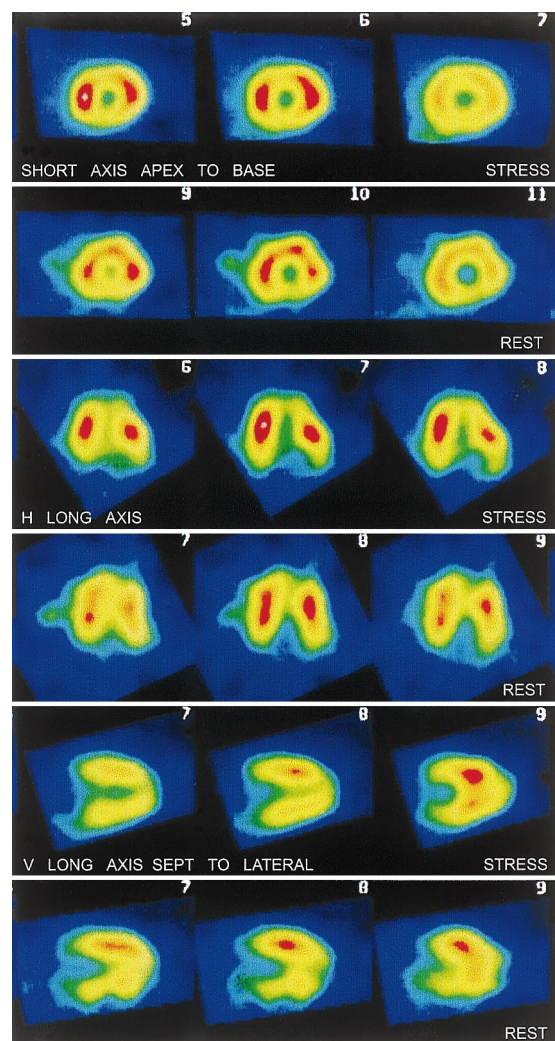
^{201}Tl SPECT at rest, and after dipyridamole stress test, in patient N66. Short axis (apex to base) and long axis (septum to lateral) slices are shown displaying 18 myocardial segments. Stress scintigrams show a ^{201}Tl uptake defect in the anterior and lateral wall that partially reversed at rest.
